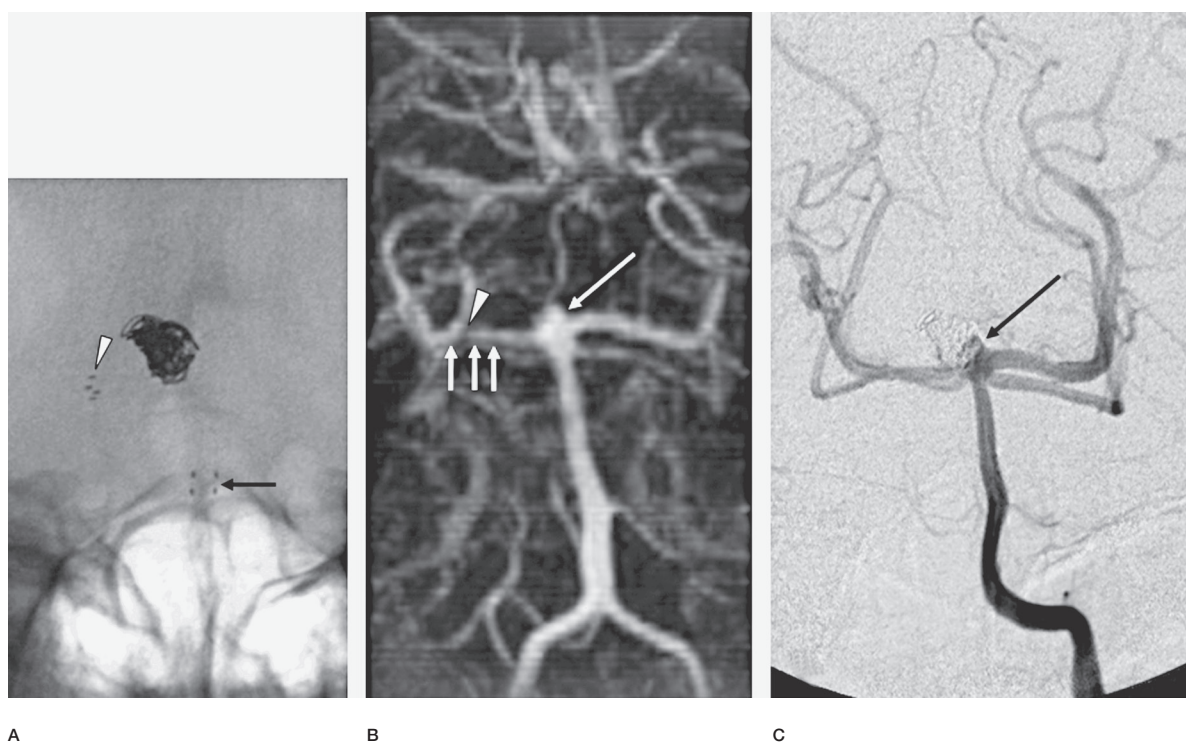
False stenosis of parent artery and “marker band effect” on CE-MRA. A) Plain film in AP projection post stent-assisted coiling of a basilar tip aneurysm shows the proximal marker bands of the Neuroform stent (arrow) located in the mid-basilar artery and the distal marker bands (arrow head) located in the P1-P2 junction of the PCA. B) AP MIP reconstruction of CE-MRA demonstrates a small aneurysmal remnant (long arrow) as well as the “marker band effect” at the distal marker bands (arrow head) but not at the proximal marker bands (short arrows). C) AP projection of left vertebral artery injection from IA-DSA does not show narrowing of the right P1 segment nor does it show the marker band effect. The aneurysmal remnant is similar in size on both modalities (long arrow in B and C).
